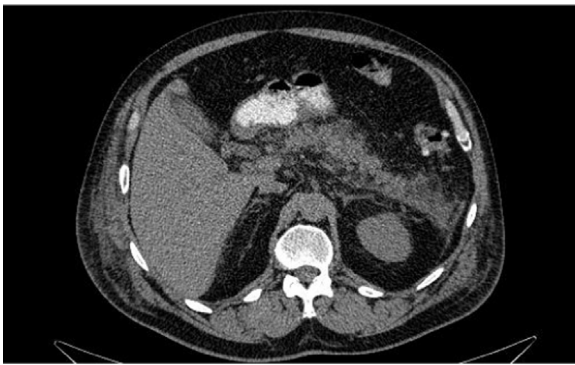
An abdominal CT scan. Bulky heterogeneous pancreas with severe peri-pancreatic inflammation extending to region of splenic hilum.
